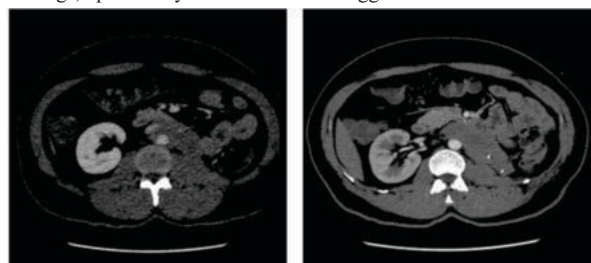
Figure A,B: Contrast enhanced axial CT image showing mildly enhancing soft tissue mass in the post operative bed extending into the retroperitoneum focally encasing the aorta and the IVC.
